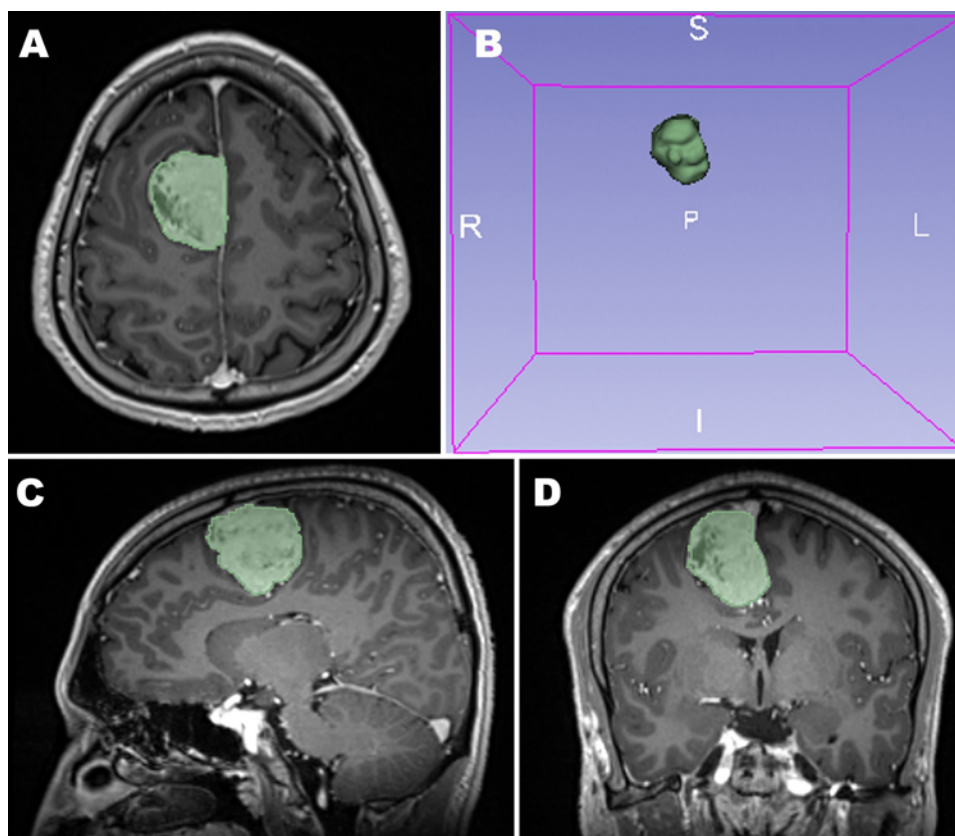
Representative example of manual segmentation used for radiomic analysis. Contrast-enhanced T1-weighted MR images showing the segmented meningioma in axial (A), sagittal (C), and coronal (D) planes, together with the corresponding 3D reconstruction (B). The green mask indicates the segmentation used for radiomic feature extraction.
